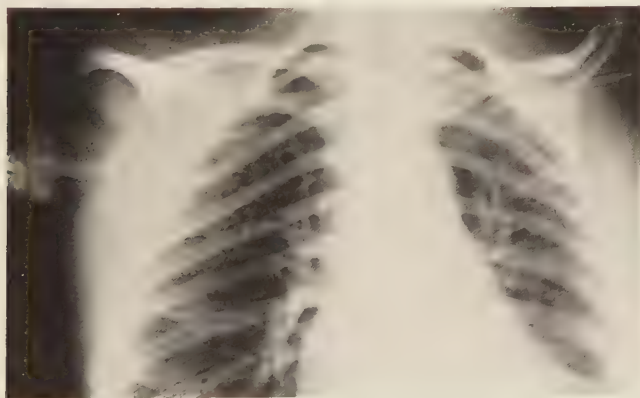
Radiograph from individual V-D.
